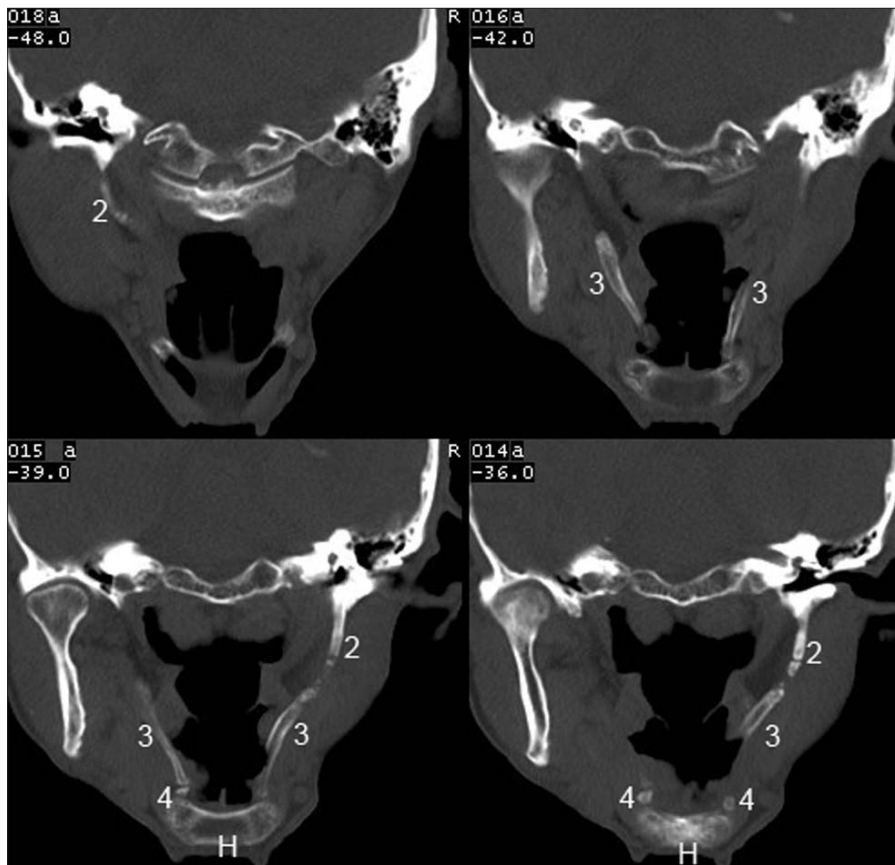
On coronal CT sections, it is possible to evaluate the parts of the stylohyoid chain bilaterally (2: tympanohyal and stylohyal segments; 3: ceratohyal segment; 4: hypohyal segment). Sections contain diffuse ossification extending towards the hyoid bone (H), and the gap in between.
